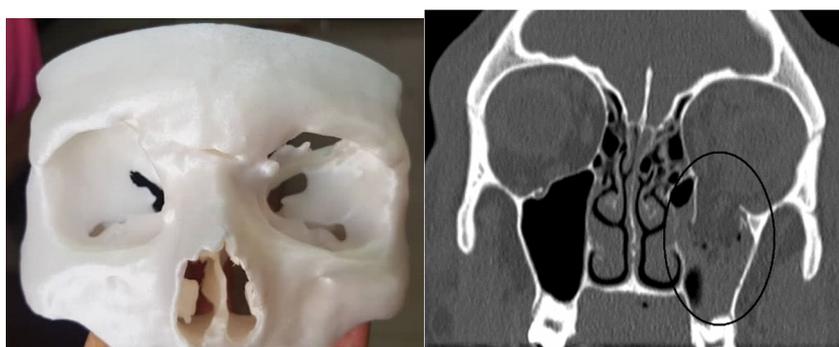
CT scan and 3D model of Orbit floor fracture
